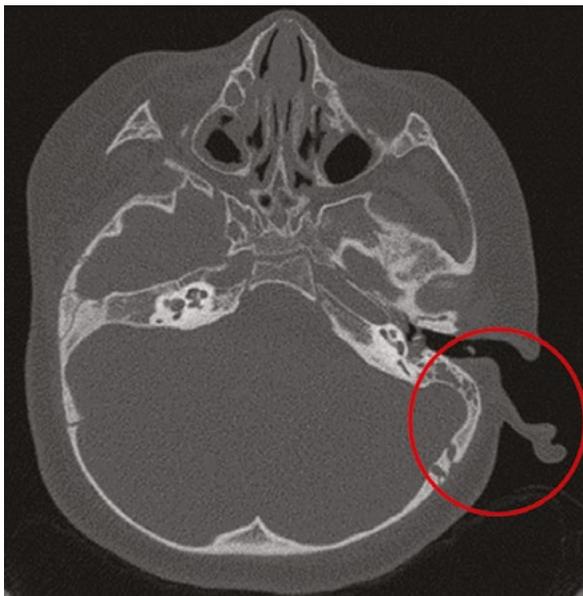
A CT data slice showing the representation of soft tissue and bone of the right ear (in red circle)
